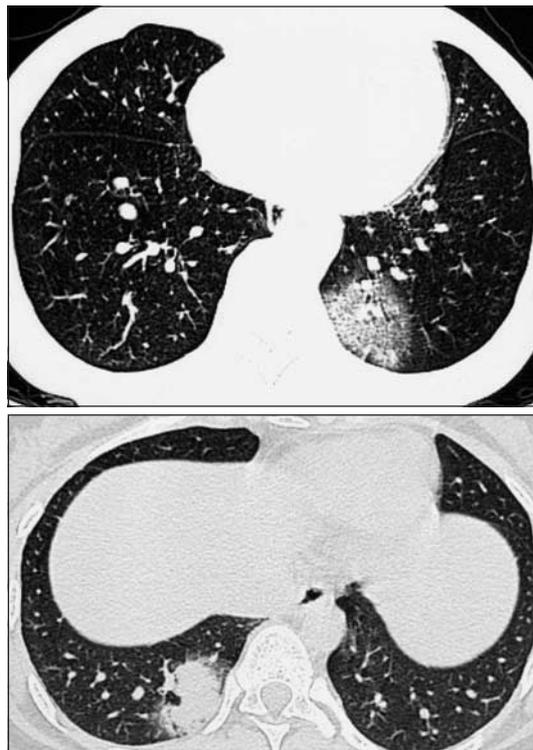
High resolution computed tomograms of two patients whose chest radiographs were normal: (above) ground glass opacification in the posterior segments of the left lower lobe (difficult to identify on a frontal chest radiograph because of location behind the heart); (below) ground glass opacification in the posterior segments of the right lower lobe (difficult to identify on a frontal chest radiograph because of location behind the diaphragm)
